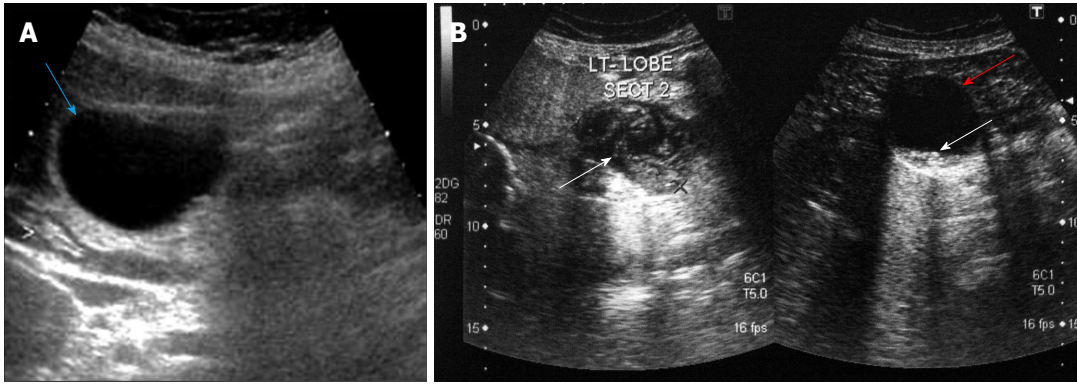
Ultrasound image. A: Showing an anechoic mass in the liver (light blue arrow), with a rather thin capsule (cystadenoma); B: Showing two echinococcal cysts. The first on the right (red arrow-right image) appears as an anechoic mass with hydatid sand (type CE1) (white arrow-right image), while in the second (on the left), the detached and folded endocyst membrane is obvious (type CE3) (white arrow-left image).
